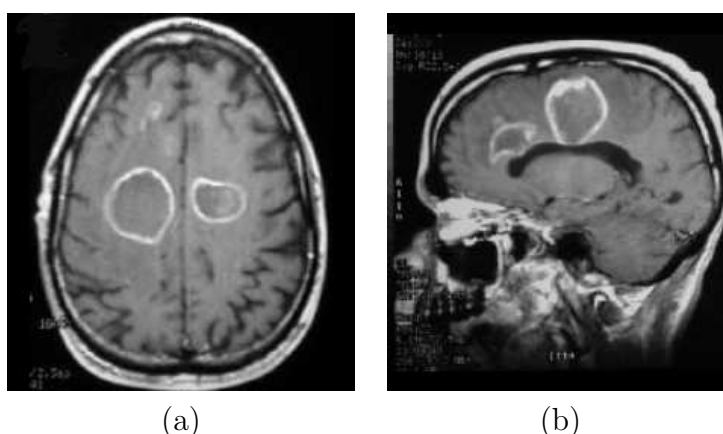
Lymphoma tumor. a) Axial contrast enhanced T1-weighted image shows ring enhanced tumor. b) Sagittal view of the same patient. [Emedicine, 2005].
